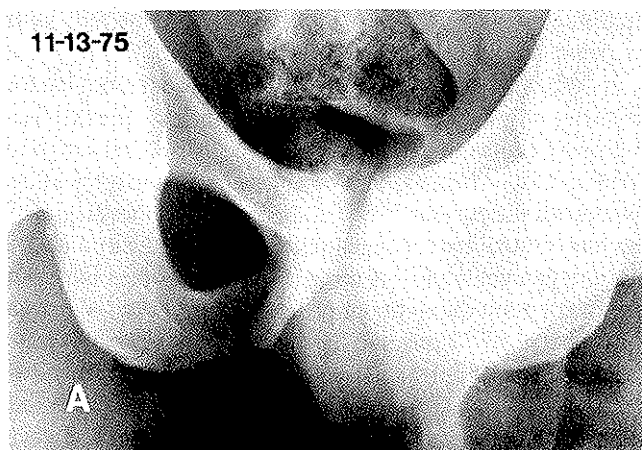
X-rays of the symphysis pubis of the football player discussed by the authors also show changes that are consistent with septic arthritis. (A) X-ray taken on the day of admission. (B) After three weeks of intravenous therapy. No surgery was performed. (C) Two months post onset, asymptomatic state.
